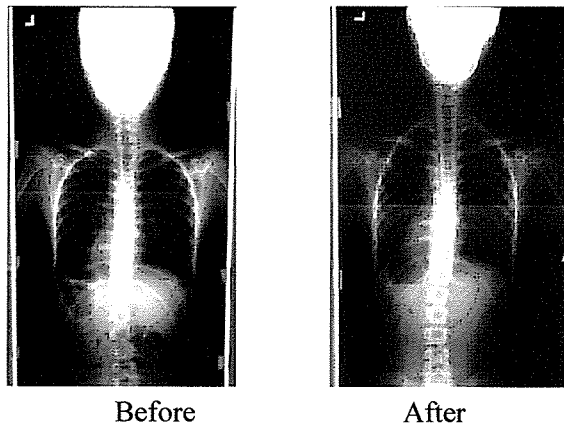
The pre and post X-ray pictures of subject B
